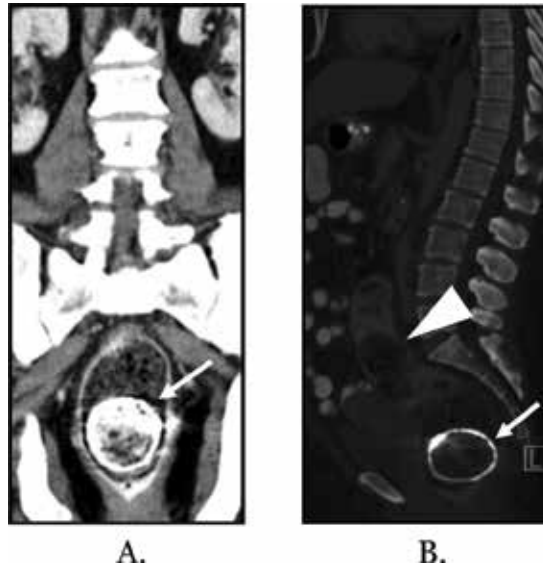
(A and B) Coronal and sagittal contrast-enhanced CT images of a patient with constipation show fecal impaction in a dilated colon and rectum (arrowhead) with a large, rim-calcified fecaloma (arrow) that causes stercoral colitis.
